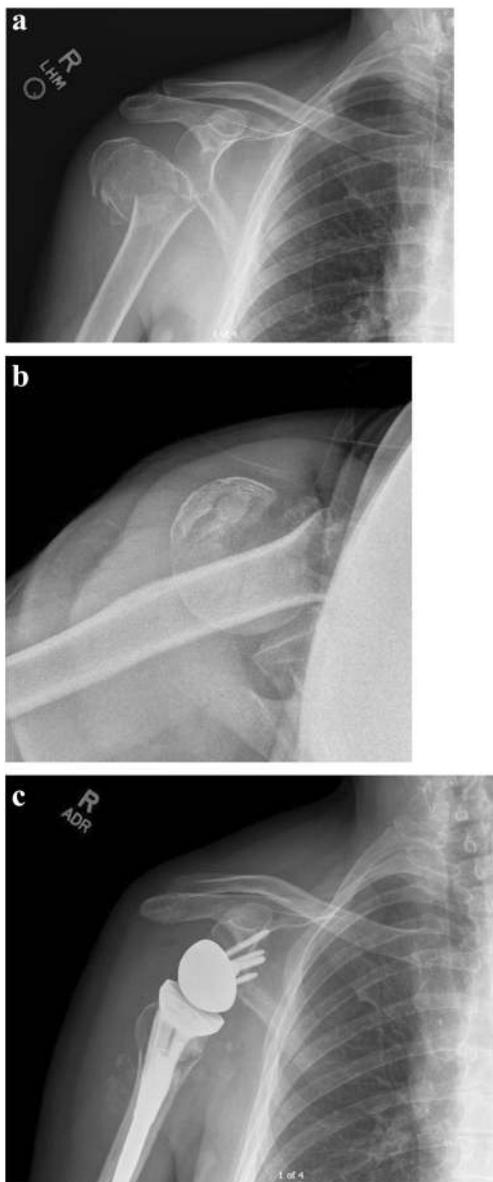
(a–c) Reverse total shoulder arthroplasty for a proximal humerus fracture. (a, b) Anterior-posterior (a) and lateral (b) radiograph of the right shoulder demonstrates a displaced four-part proximal humerus fracture. (c) Following reverse total shoulder arthroplasty with a cemented stem with suture fixation of the greater and lesser tuberosities around the humeral component
